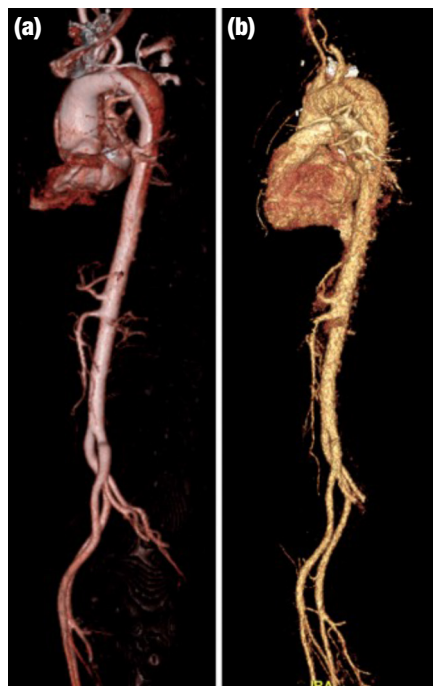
Comparison of the dissection flap by using three-dimensional computed tomography. (a) Preoperative, (b) Postoperative.
